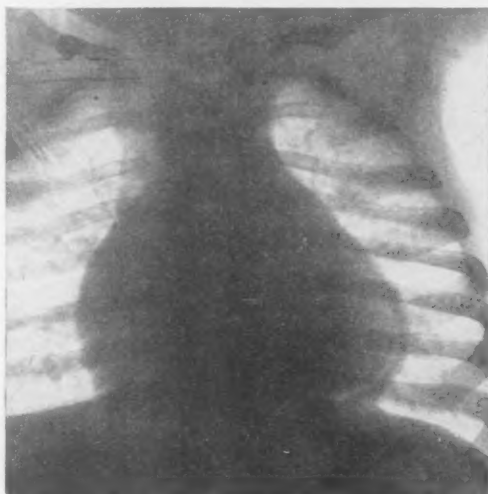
X-ray taken 24 hours after removal of pin, showing pneumopericardium on opposite side.
